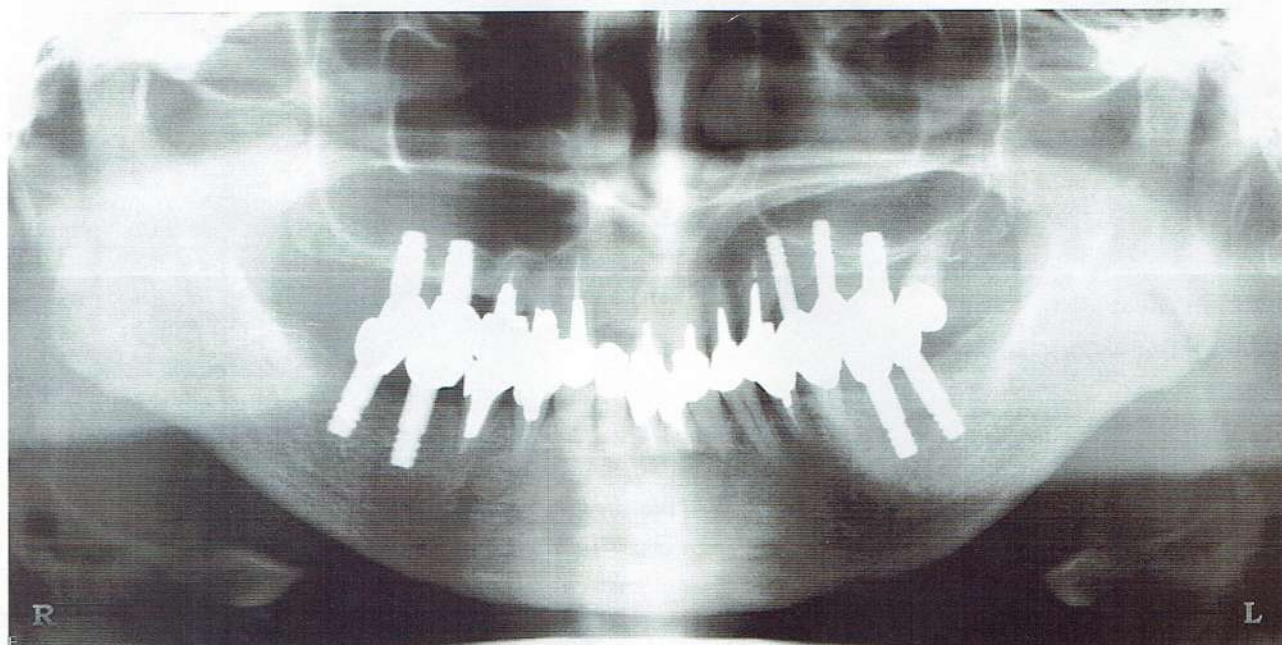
Radiograph after 4-years loading for first and second right molars, 3-years loading for first left molar showing new bone formation
